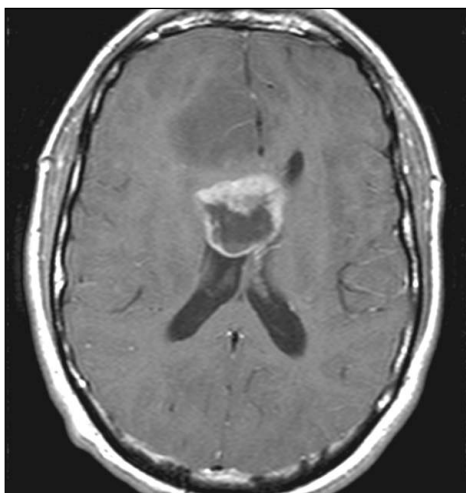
Gadolinium-enhanced, T1-weighted, axial MRI showing the tumor at the time of initial presentation.
